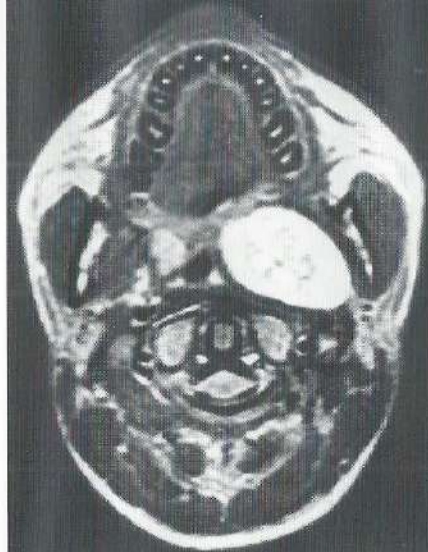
This MR T2-weighted SE image shows a well circumscribed tumour of the parapharyngeal space with an inhomogeneous and intermediate to high signal intensity.
